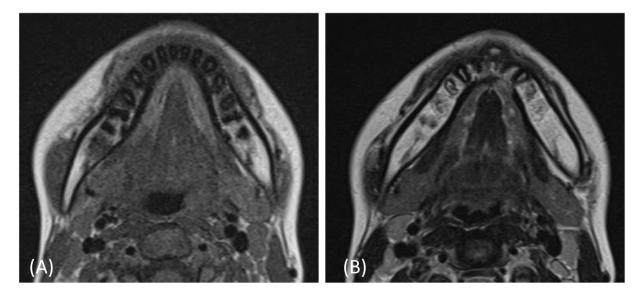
(A) Axial T1-weighted image (TR/TE = 653/11 ms) (B) Axial T2-weighted image (TR/TE = 3500/100 ms) show the sublingual glands were in contact with lingual cortical bones of the lateral incisor.
